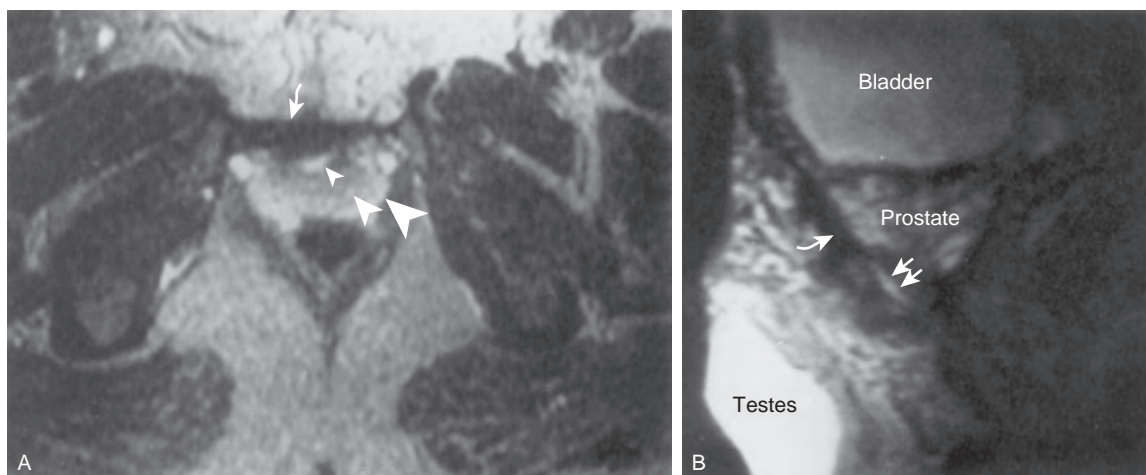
A, Axial T2-weighted image of the mid-prostate in a 20-year-old continent patient with bladder exstrophy. Small arrowhead, lumen of the urethra; medium arrowhead, transitional zone; large arrowhead, peripheral zone. Curved arrow, fibrous band of the intersymphyseal bar. B, Sagittal T2-weighted image through the mid-prostate gland shows anterior urethra (double arrows) and posterior prostate gland. Intersymphyseal fibrous band (curved arrow) extends along the entire length of the prostate.
